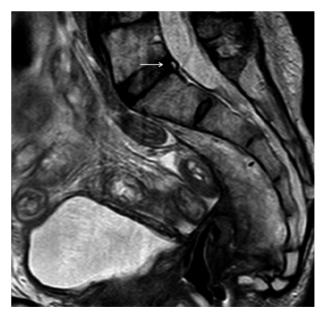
Sagittal view of MRI (T2 sequence) showing a HIZ at the L5-S1 disc (arrow)
